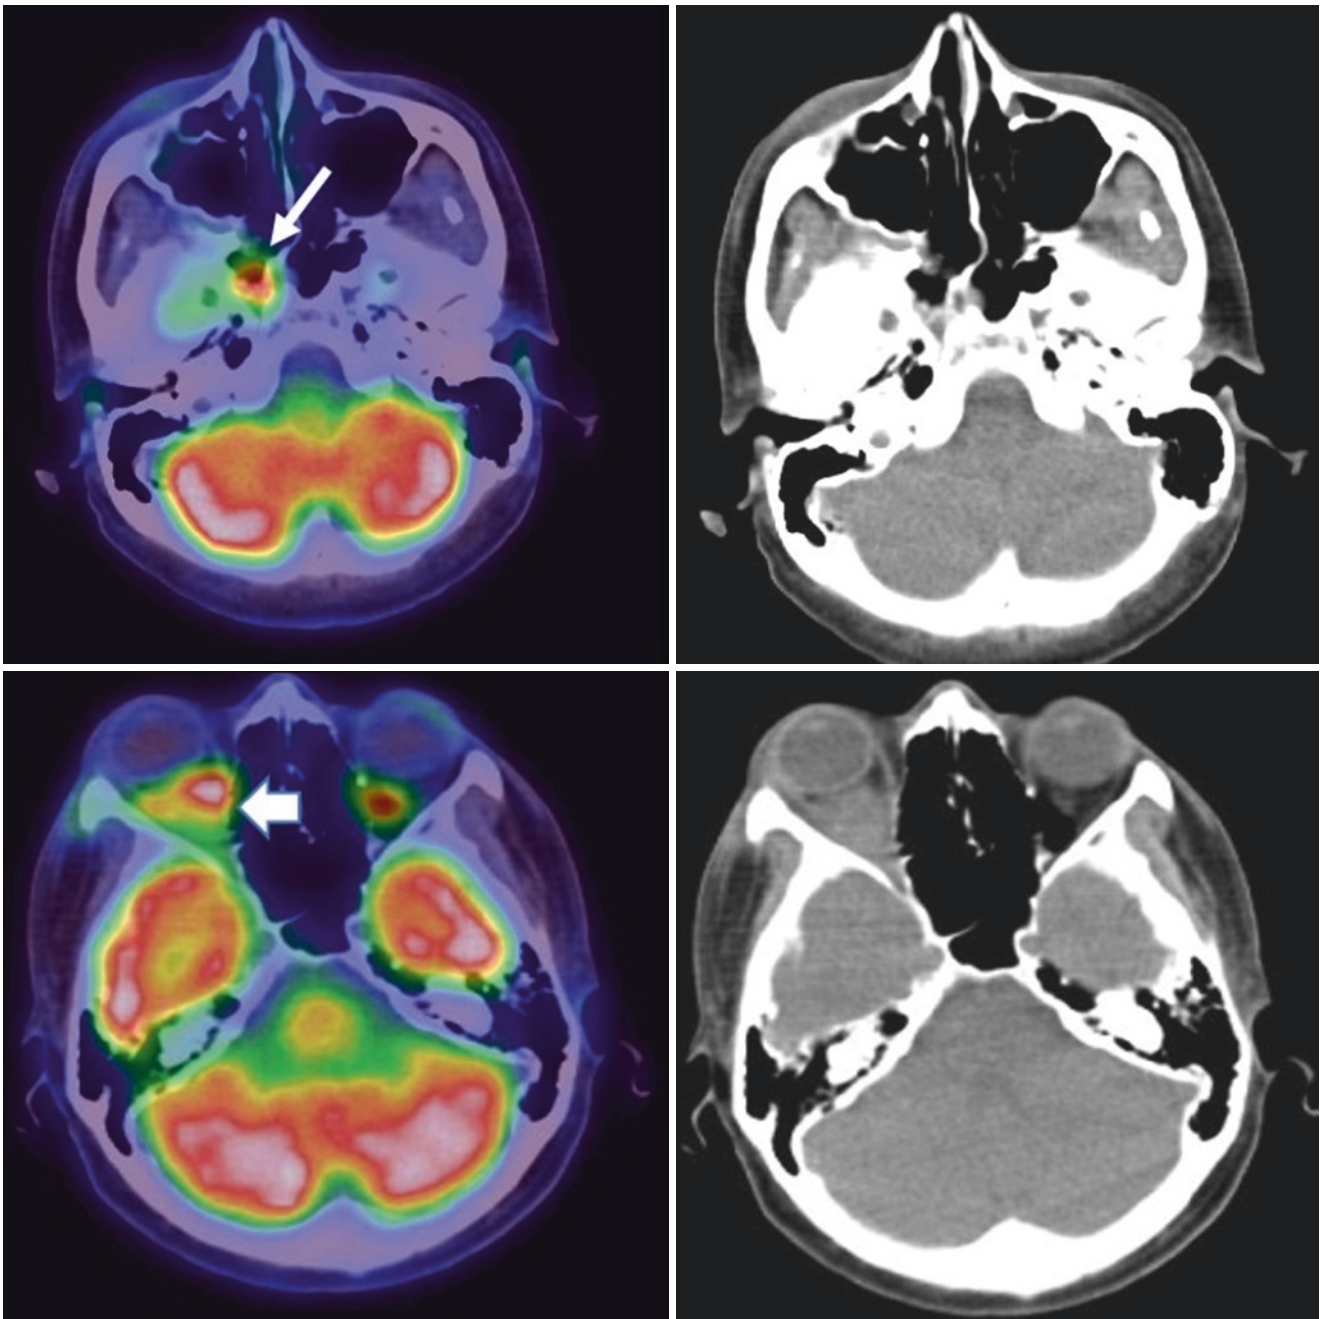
Fused PET-CT and CT images showing the FDG-avid tumour in the roof of the nasopharynx (white arrow) and in the orbit (black arrow)
